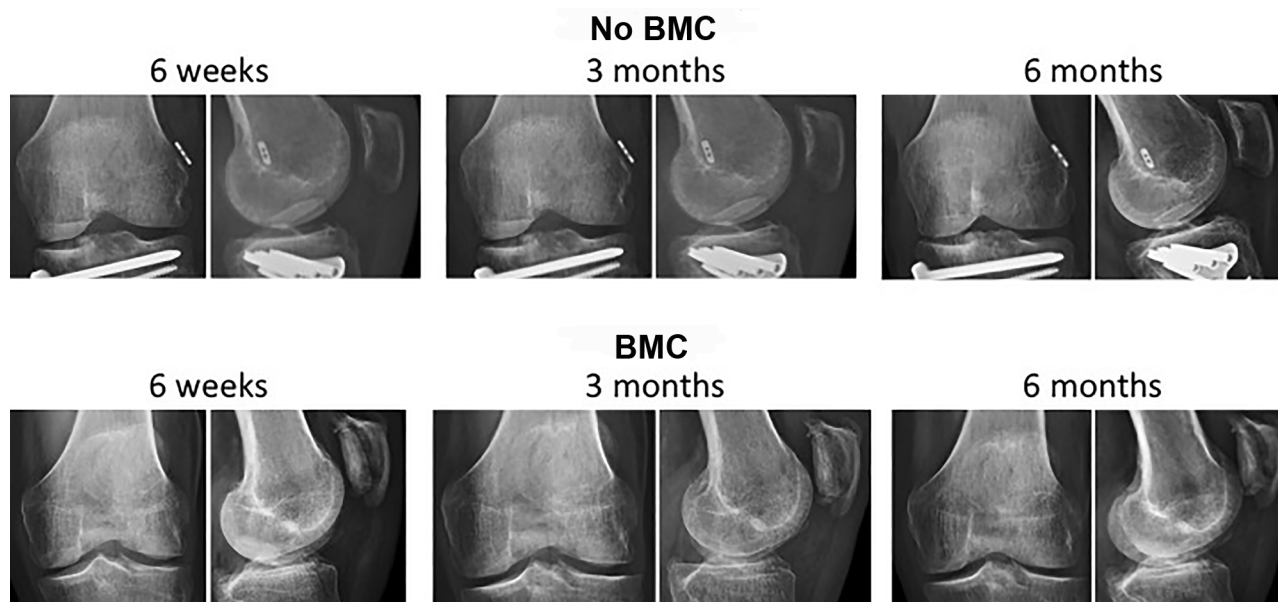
Representative radiographs displaying transplanted osteochondral allografts at 6 weeks, 3 months, and 6 months. BMC, bone marrow aspirate concentrate.
